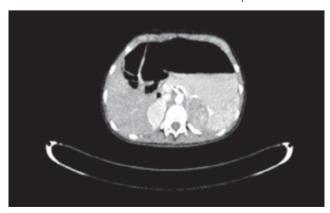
Arterial phase computed tomography of the adrenal masses
